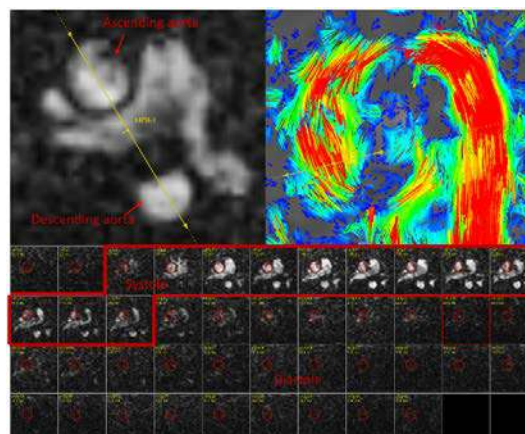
Velocity extraction of 4D-MRI images with Mass.
